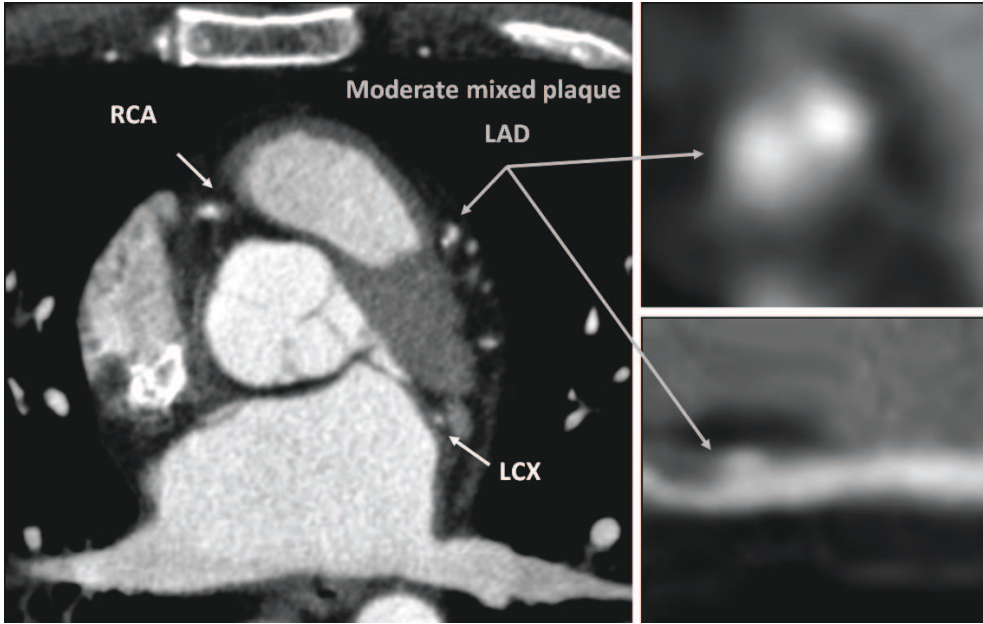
Visualization techniques used to interpret CTA images: transaxial (left) and multi-planar images (cross-sectional view at the upper-right, longitudinal view at the bottom right). Left anterior descending artery (LAD), right coronary artery (RCA) and left circumflex artery (LCX). This patient (training dataset #05) presents a moderate mixed plaque in segment #8 of the LAD.
